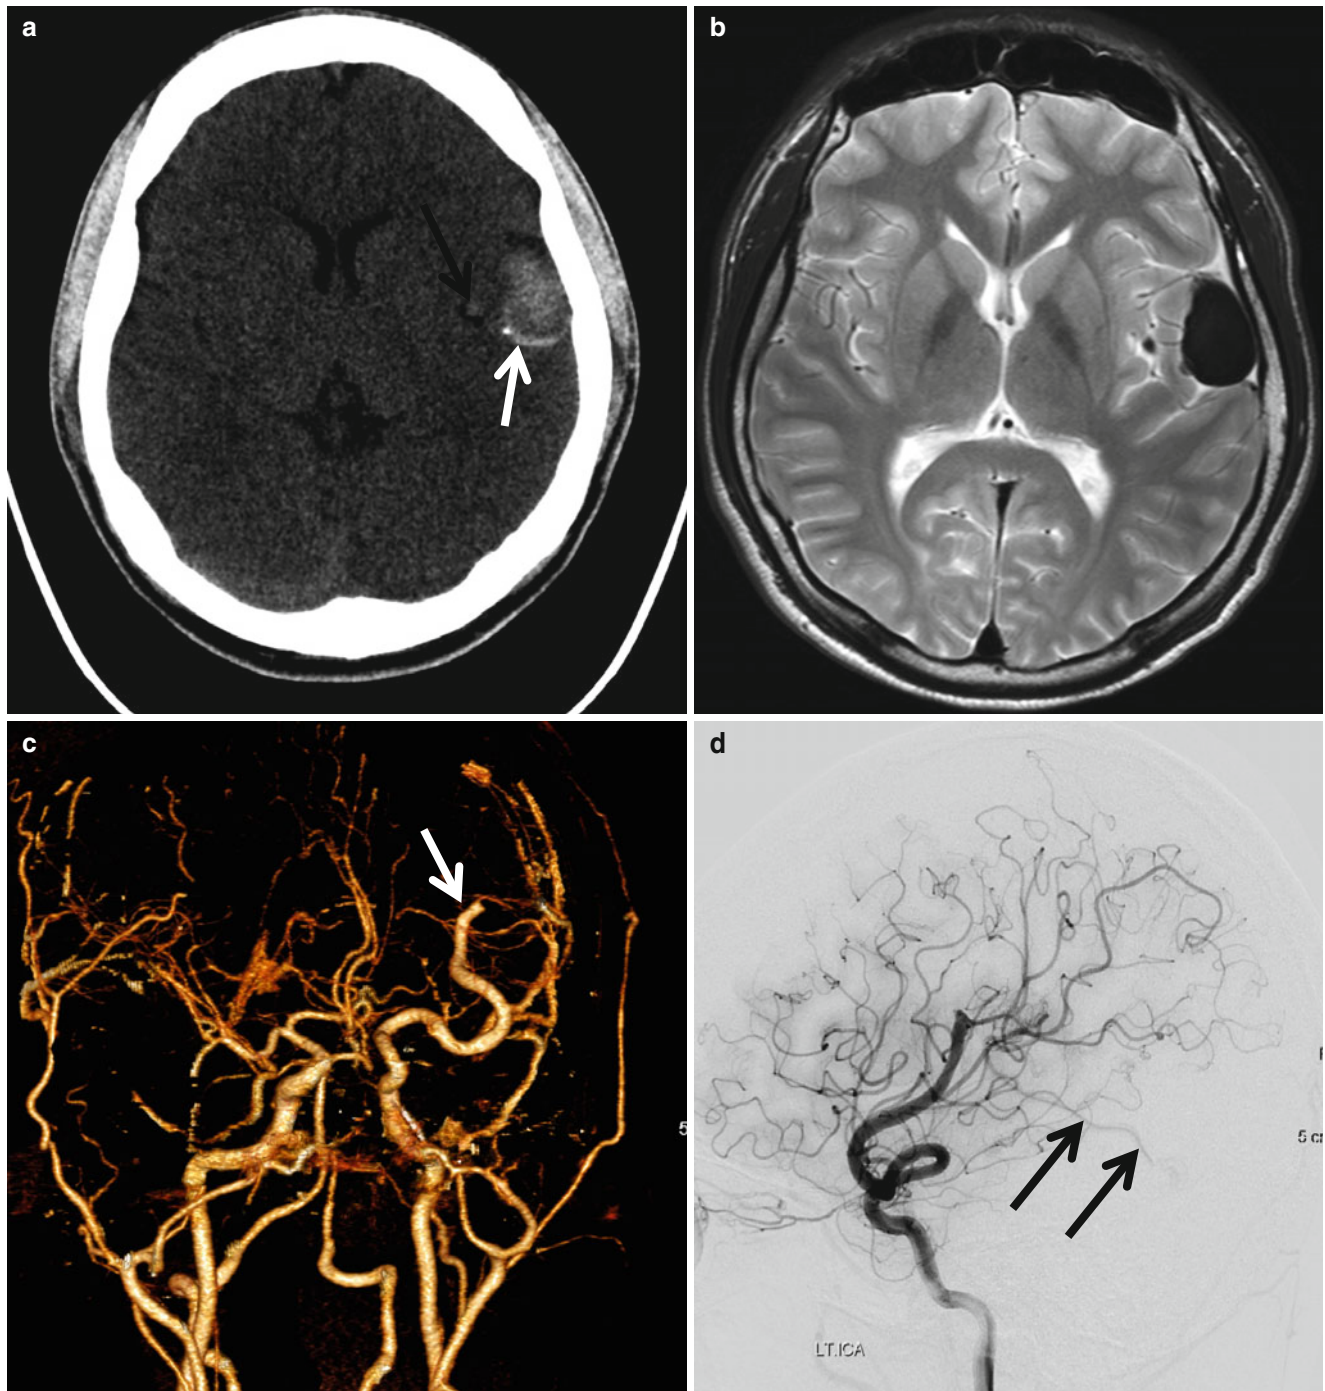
Pial AV fistula in 2-year-old boy. (a) Precontrast CT shows hyperdense mass (dilated venous pouch, *white arrow*) in the left temporal region with tiny marginal calcification. A dilated vessel (*black arrow*) of same density is seen at the medial aspect of the mass. (b) T2-weighted image reveals dark signal intensity of the dilated venous pouch. (c) Oblique AP view of the CT angiography shows abruptly
